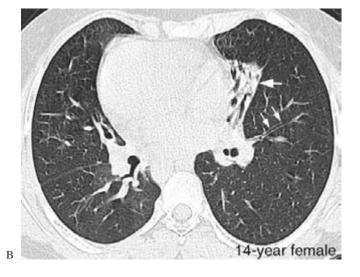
1 Kartagener's syndrome in siblings. A. Plain chest radiogram from a 14-year-old girl shows situs inversus and dextrocardia. The left middle lobe is collapsed. B. Lung computed tomograph of the same patient shows bronchiectasis in the collapsed right middle lobe (arrow) and bronchial thickening (arrows). C. Plain chest radiogram of the 4-year-old brother shows similar findings.
